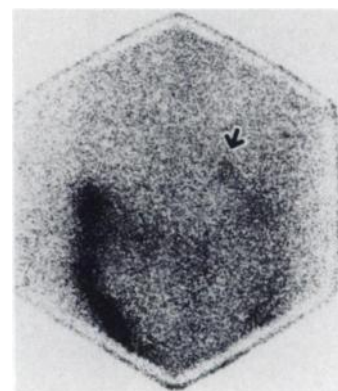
Adrenocortical scintigram 8 days after injection. Tracer uptake in the right adrenal gland (arrow) is demonstrated while no accumulation of tracer in the left adrenal gland is evident.
